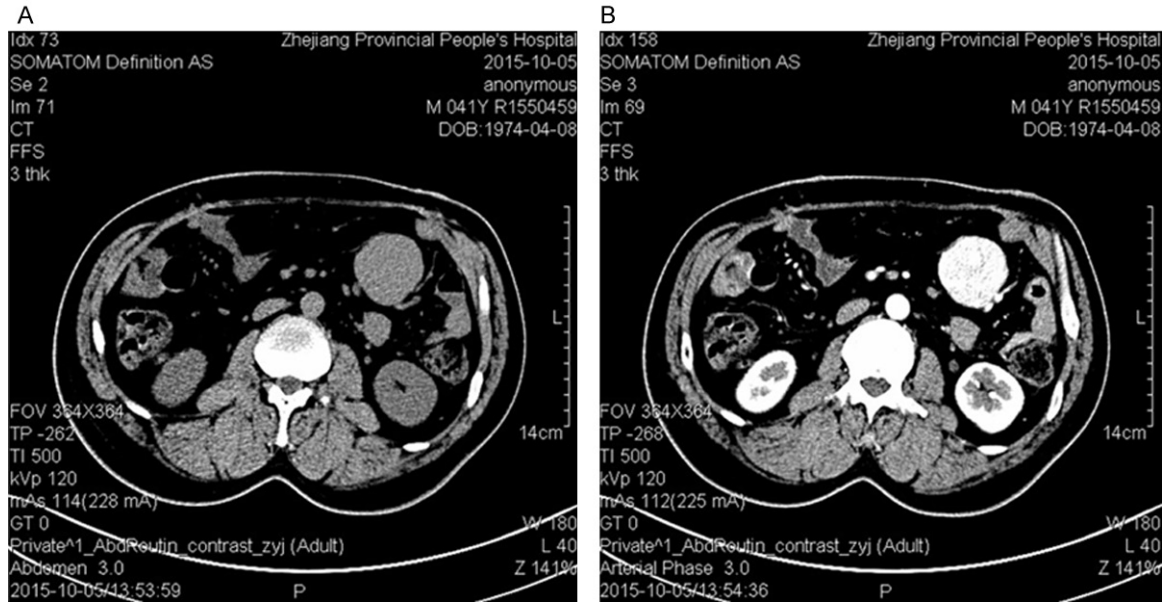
Patient abdominal CT scan (A) The unenhanced abdominal CT scan showed that a round mass with homogeneous density existed in the mesentery. The mass has a smooth border with a clear boundary. (B) Contrast-enhanced CT scan revealed marked homogeneous enhancement.
